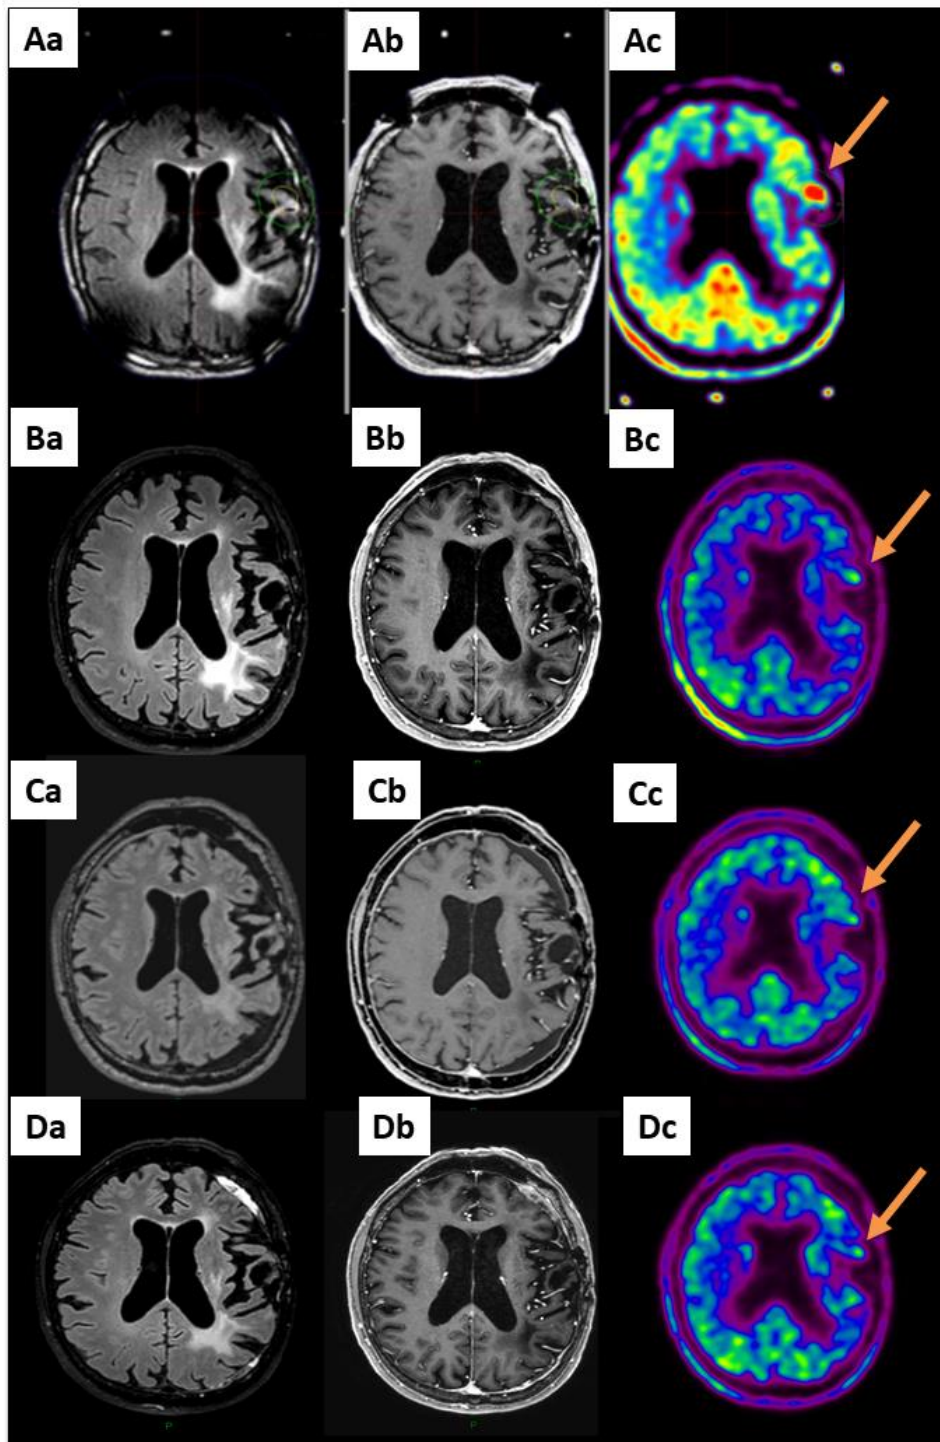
A 63-year-old patient with a grade II evolvable astrocytoma (AII) (patient 19 in Table S1) already treated by PCV chemotherapy, radiotherapy and TMZ chemotherapy after large surgical resection received GKRS treatment 20 Gy on a volume of 2312 mm³ including the MET-PET target (arrow). Aa: MRI reformatted axial FLAIR, Ab: reformatted axial T1-weighted with contrast and Ac: MET-PET study performed on the day of the GKRS treatment. B, C and D show the same sequences 3, 6 and 12 months after GKRS: long-term local response.
